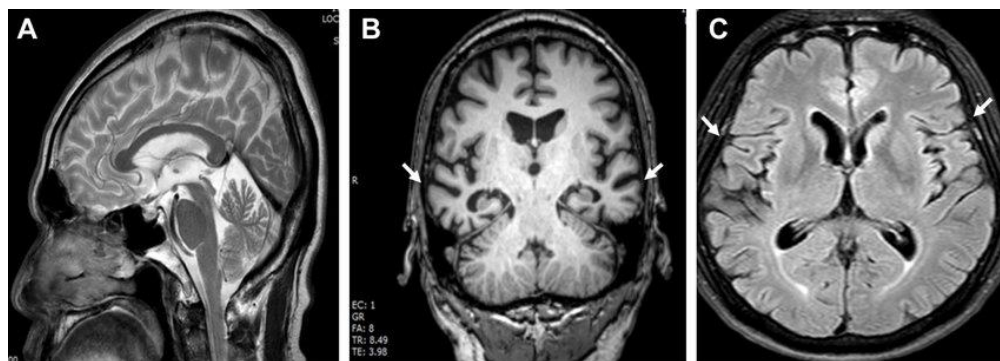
Structural MRI sequences. (A) T1-weighted MRI image of the patient with Alzheimer's disease with sagittal view. (B) Coronal T2WI. (C) Axial T2WI. Note: The arrows point to the hippocampal atrophy. Abbreviation: MRI, magnetic resonance imaging [24].
